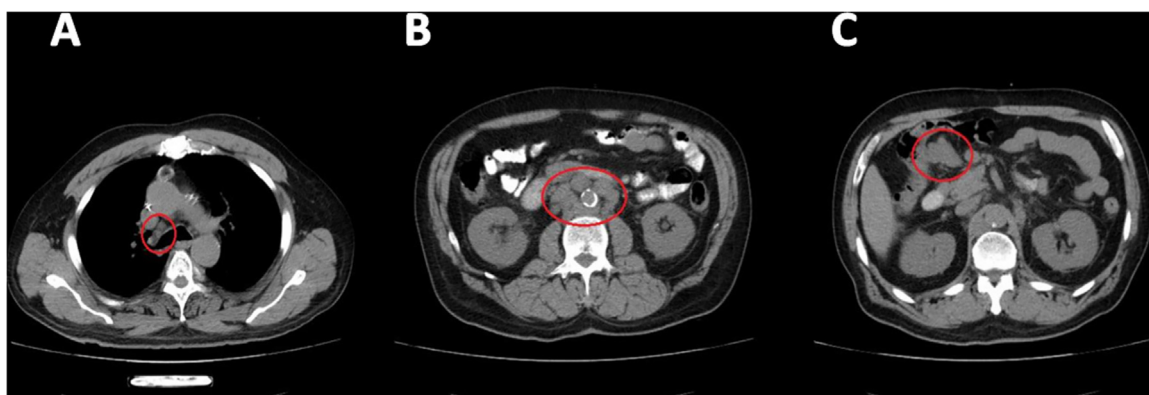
Computed tomography CT scan of the chest abdomen and pelvis showing: (a) small adenopathies in the Bary's space (the largest one measuring 13 mm), (b) multiple adenopathies in the retroperitoneal space (the largest one measuring 3 cm in diameter), and (c) a 6 cm mass attached to the right colon proximal to the liver flexure.
